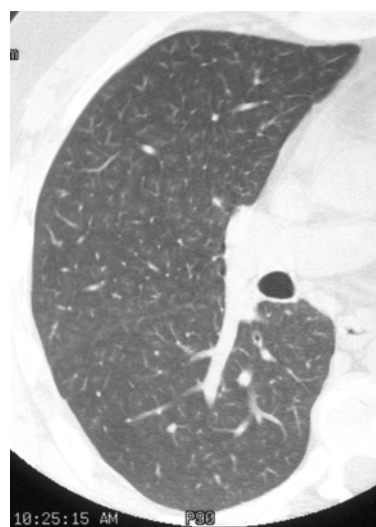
Respiratory bronchiolitis-interstitial lung disease (RB-ILD) in smoker: HRCT scan shows diffuse, ill-defined, centrilobular ground glass opacities.
